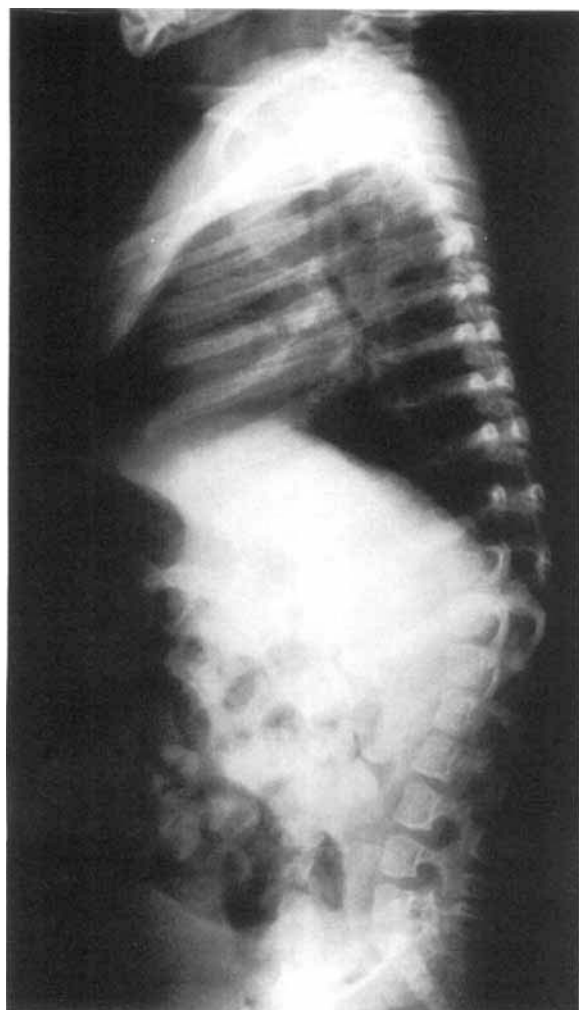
Spine radiograph lateral view. Note foreshortening of vertebral bodies.
